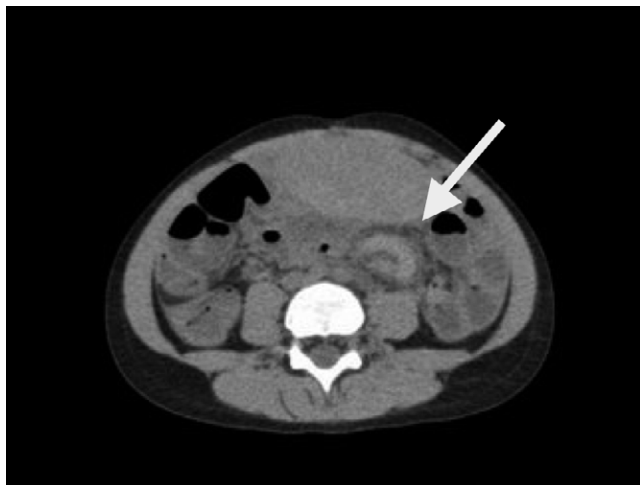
Computed tomography scan showing the spleen in the pelvis. The *whirl sign* (arrow) indicates torsion of the vascular pedicle.
